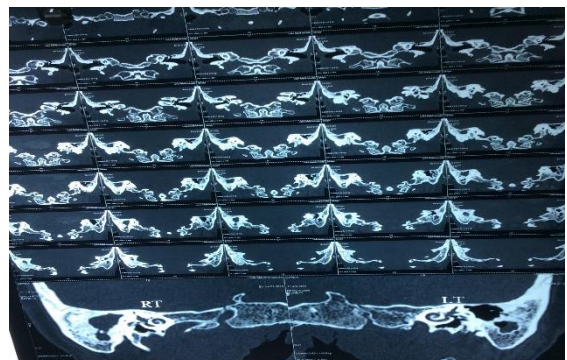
HRCT showing cholesteatoma
